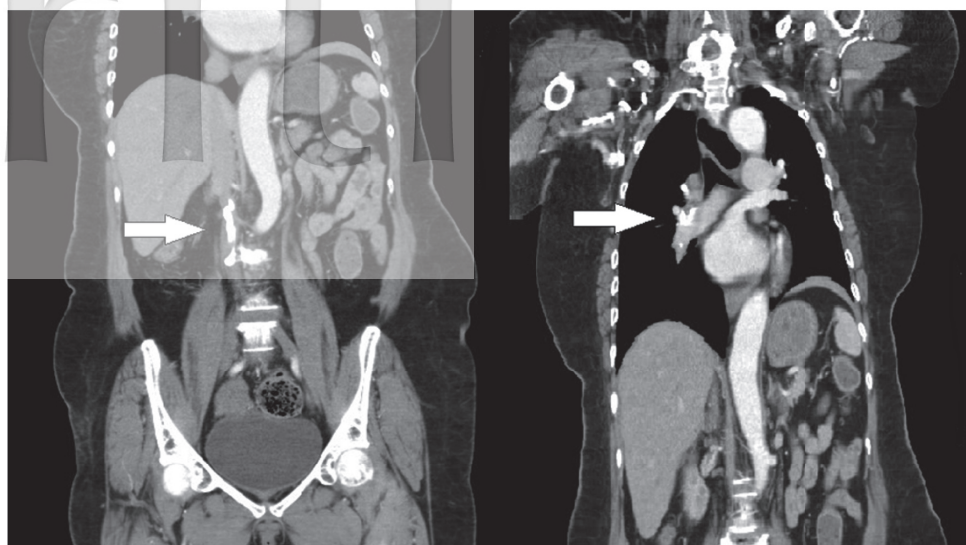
Abdominal and chest computed tomography (CT) images show the presence of cement emboli in the third lumbar spine, inferior vena cava, and right pulmonary trunk.
